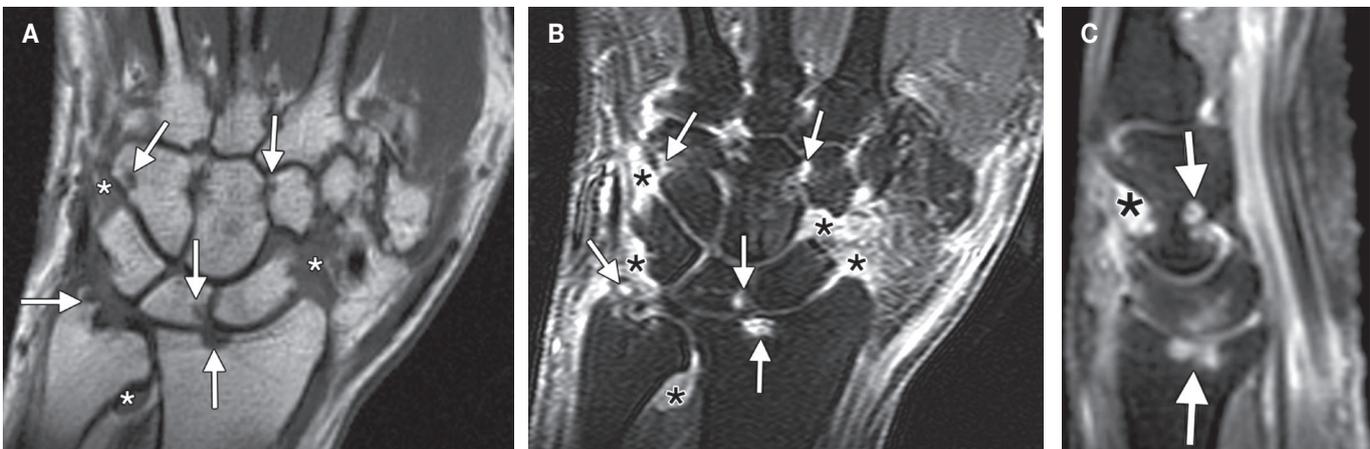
Erosions in early rheumatoid arthritis of the wrist (1 year duration) with normal radiographs. (a) Coronal T1-w MR image shows extensive synovitis (*), along with multiple erosions of the carpal bones, distal radius, and ulnar styloid process (arrows). Coronal (b) and sagittal (c) contrast-enhanced fat-suppressed T1-w MR images again show extensive synovitis (*), with marked enhancement of the multiple erosions (arrows) seen in a. Erosions of the distal radius and lunate bone are seen in both planes.
